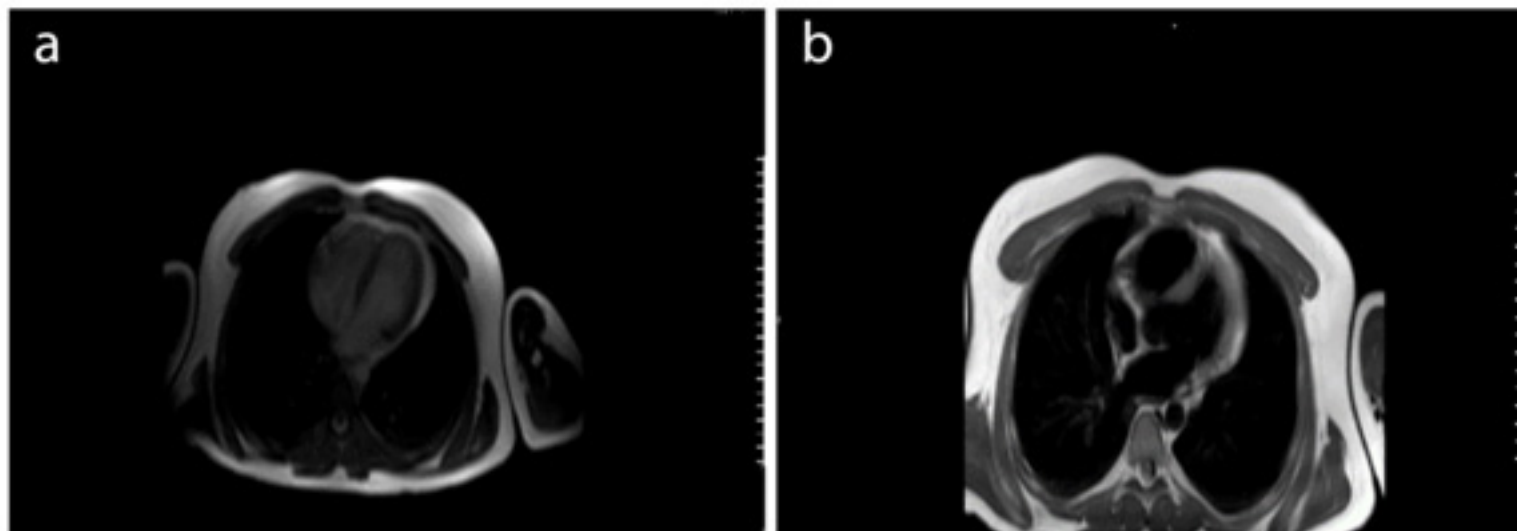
(a and b): CMR findings on MRI consistent with myopericarditis
